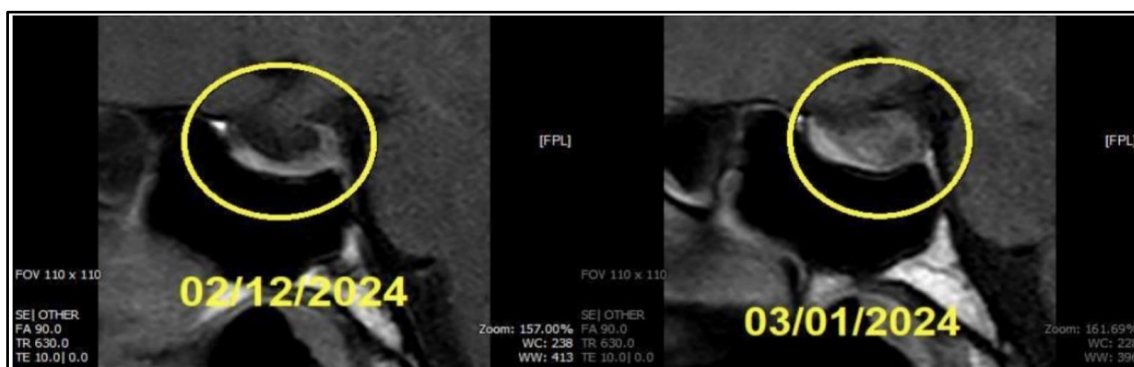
Sagittal T1-weighted MRI comparison of the pituitary gland showing a significant increase in the size of a sellar/suprasellar mass between February and March 2024.
